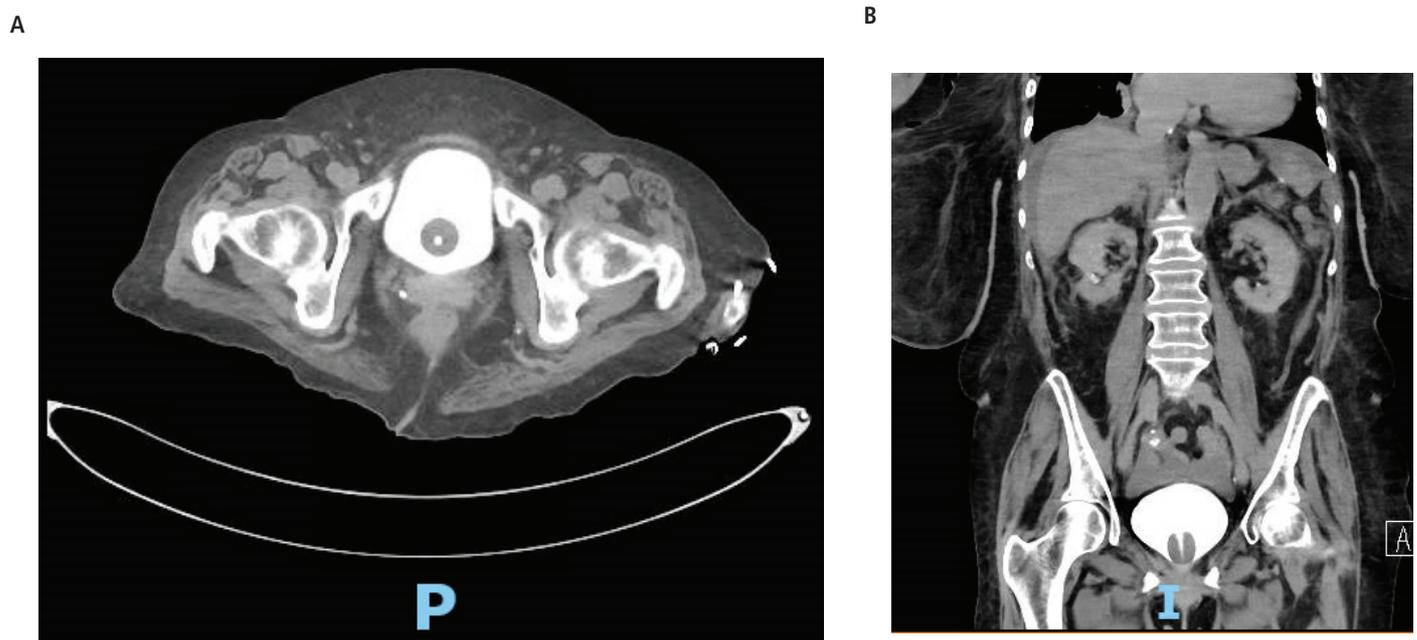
A, B, CT cystogram showing Foley in place inside normal bladder. Pelvic ascites has been displaced upward into abdominal cavity.
